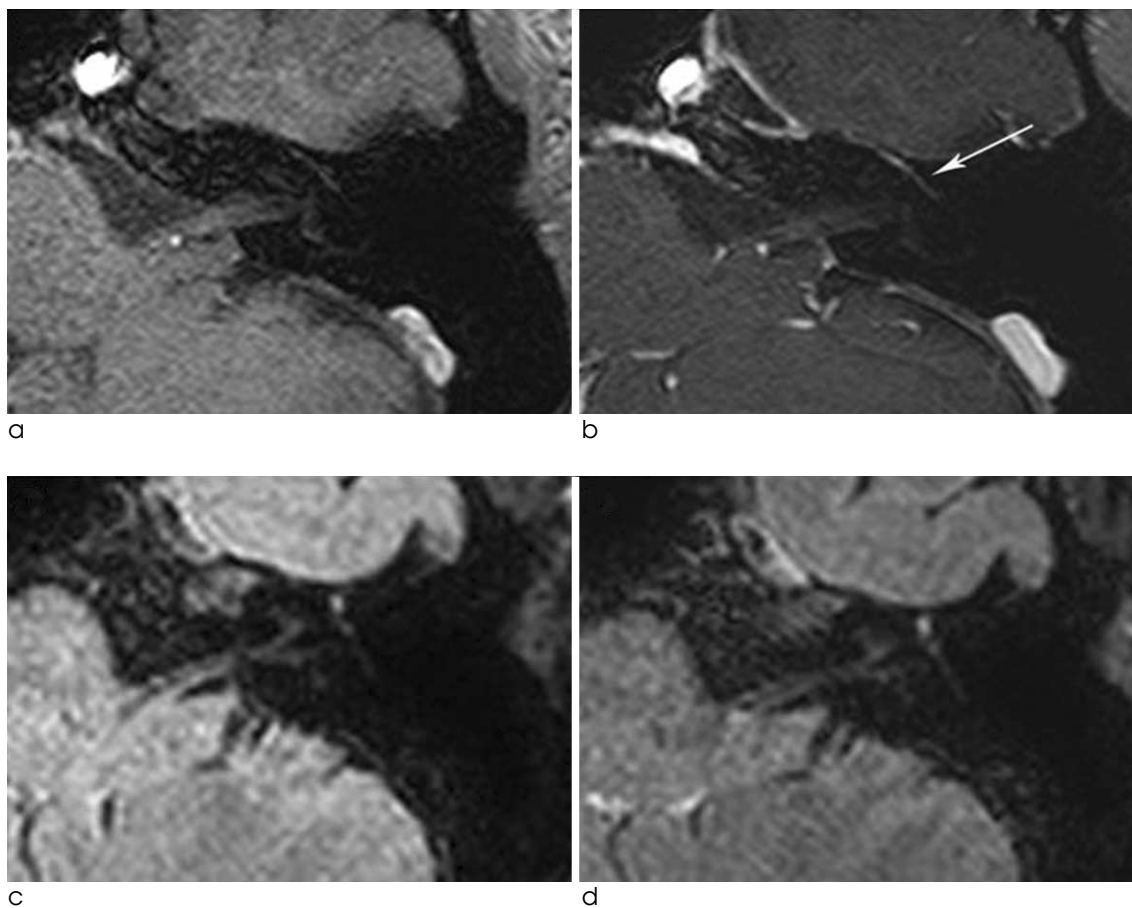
Example of a normal facial nerve on 3D-FLAIR and 3D-T1-FFE-FS images before and after administration of a contrast agent. Axial MR images of the left temporal bone on 3D-T1-FFE-FS (a, b) and 3D-FLAIR (c, d) images. On 3D-T1-FFE-FS, the tympanic segment of the left facial nerve was mildly enhanced (arrow on b) compared with that on the pre-contrast image (a). However, there was no demonstrable enhancement on the corresponding pre- (c) and post- (d) contrast images of the 3D-FLAIR sequence.
